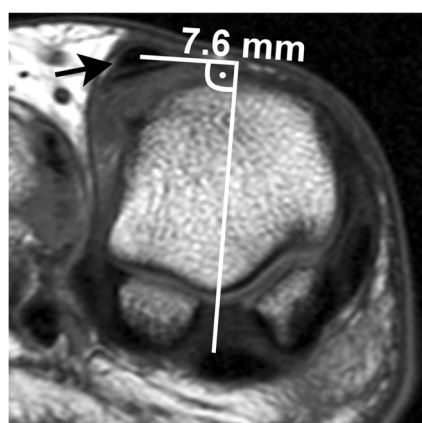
28-year-old woman. Lateralization of the extensor hallucis longus tendon (*arrow*) (EHL) was quantified as the distance (7.6 mm) between the dorsoplantar midline of the first metatarsal head and the centre of the EHL tendon on transverse T1-weighted MR images
